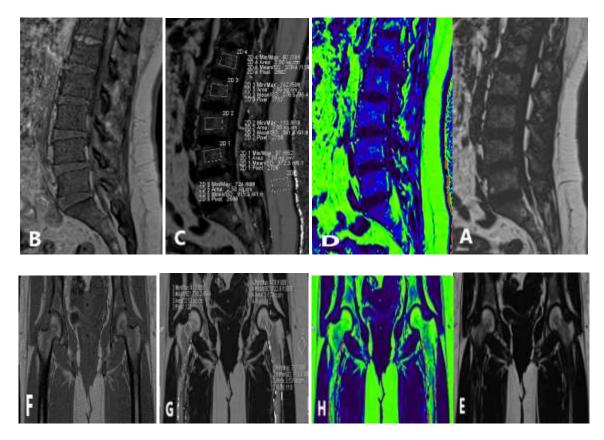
Control case (A, B, C, D) Sagittal lumbosacral spine Dixon MRI fat only image, add (fat + water), divide image (FF = FO/FO+WO) and colored fat fraction map respectively with FF measuring about 40%. (E, F, G, H) Coronal both hips Dixon MRI fat only image, add image (fat + water), divide image (FF = FO/FO+WO) and colored fat fraction map respectively with FF measuring about 78%.
